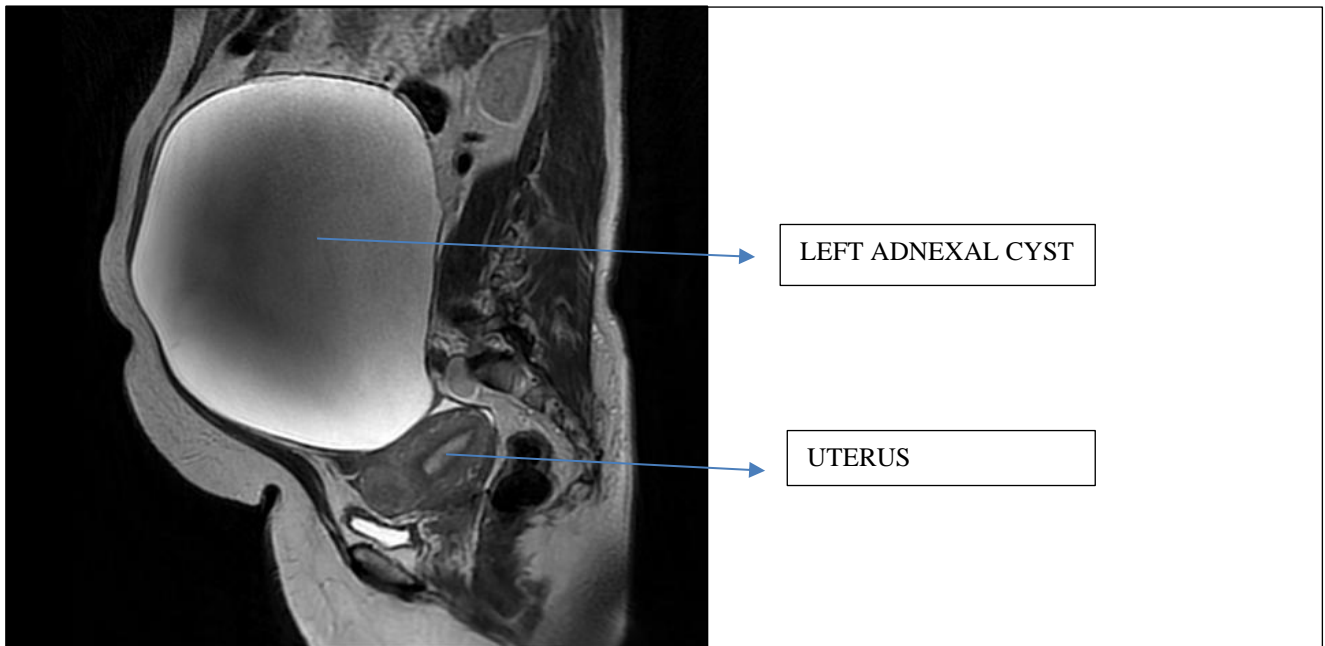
MRI pelvis showing large adnexal cyst which is separate from the uterus.
